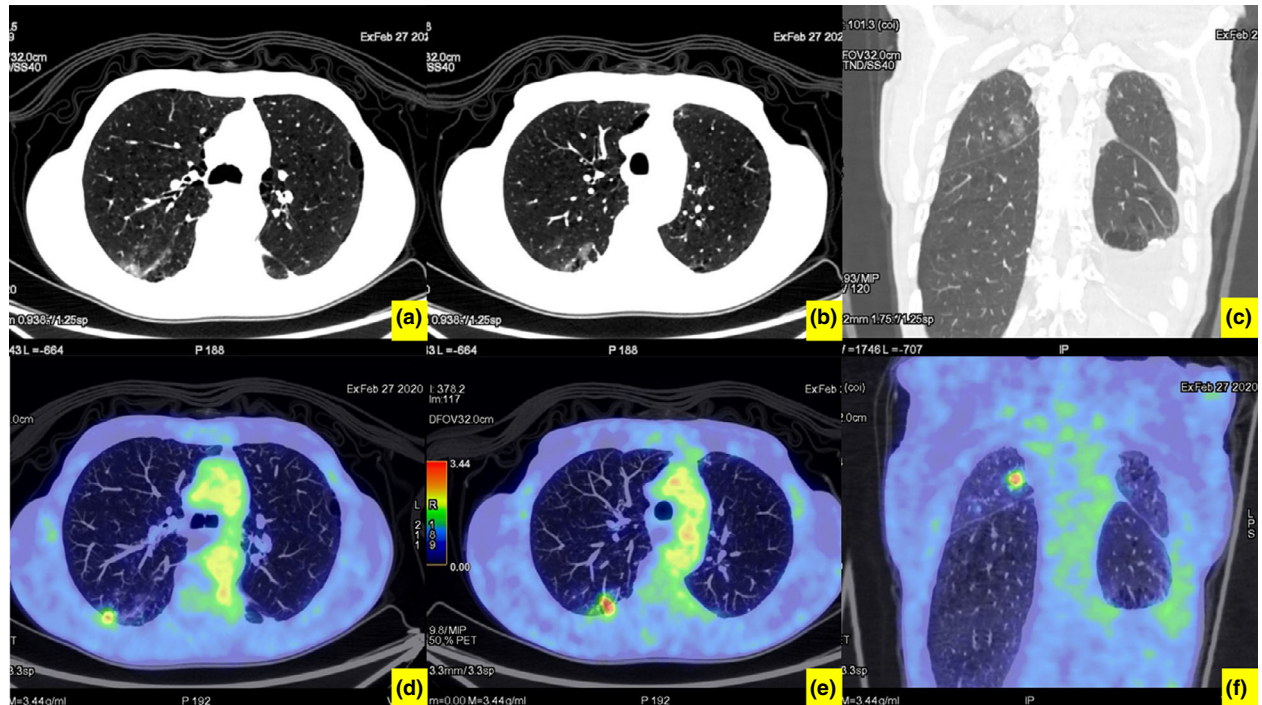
High-resolution CT transaxial (a, b) coronal (c) and ^{18}F -FDG PET/CT transaxial (d, e) coronal (f) images.
